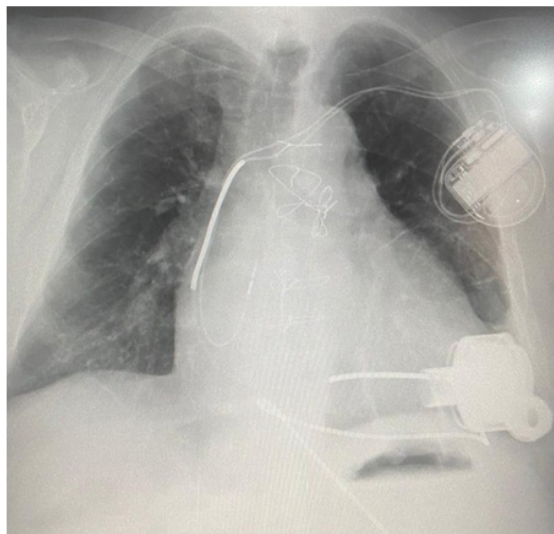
Chest X-Ray film three weeks after medical treatment without ground glass opacities.
